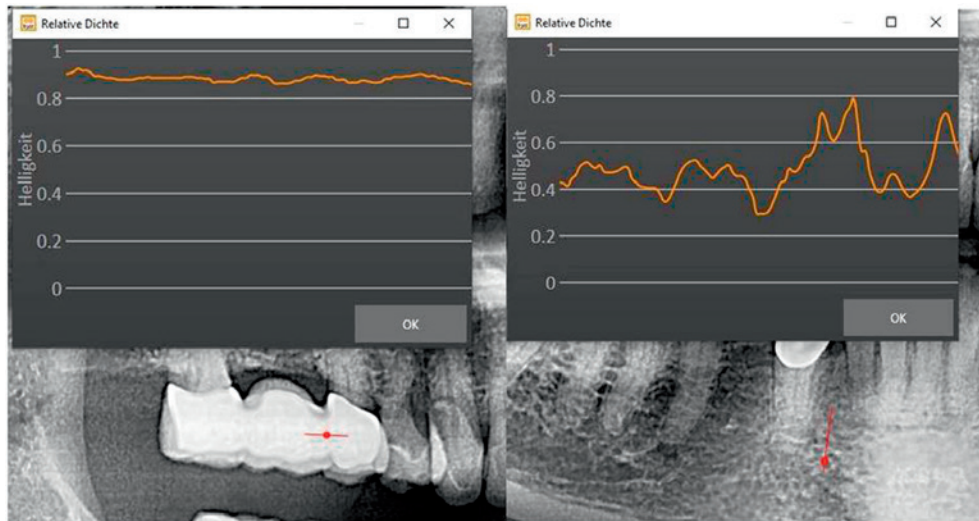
Example of measurement of relative bone density using OPG. The attenuation coefficients are displayed over the entire test section as a progression curve. In the present validation, only the mean values are used. Measurement of relative jawbone density (rel-JBD) values with an Orangedental PaX-i3D Duo 3D Multi. Legend: Red lines mark the measuring range to display the relative density in the 2-D OPG. OPG = orthopantomogram.
